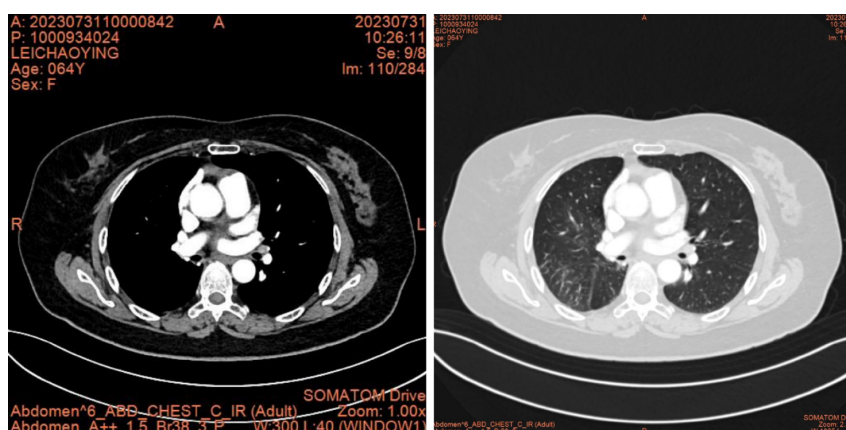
Serial computed tomography images. A: Computed tomography (CT) after postoperative recurrence; B: CT after 1 month of gefitinib therapy. Progressive disease of the lung was detected; C: CT after 53 months of crizotinib therapy. Stable disease was detected.
